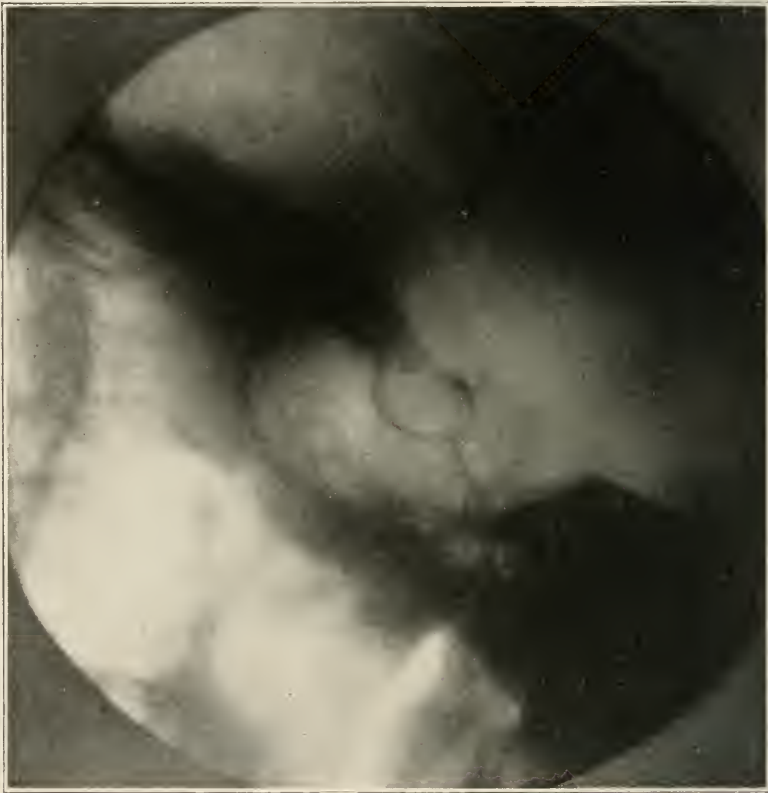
Lateral roentgenogram of sellar region showing area of increased density.
